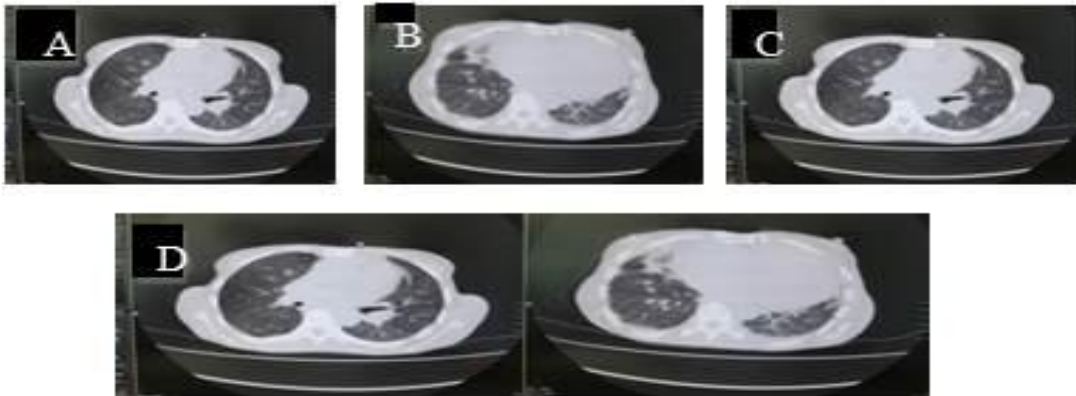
A. HRCT finding of interlobular septal thickening and ground-glass attenuation was atypical, B. Paraseptal emphysematous changes in the bilateral lower lobes, C. Reticular and linear septal thickening with collapse of bilateral upper lobes – fibrotic changes, D. Bronchiectatic changes in the posterior segments of right upper lobe.
